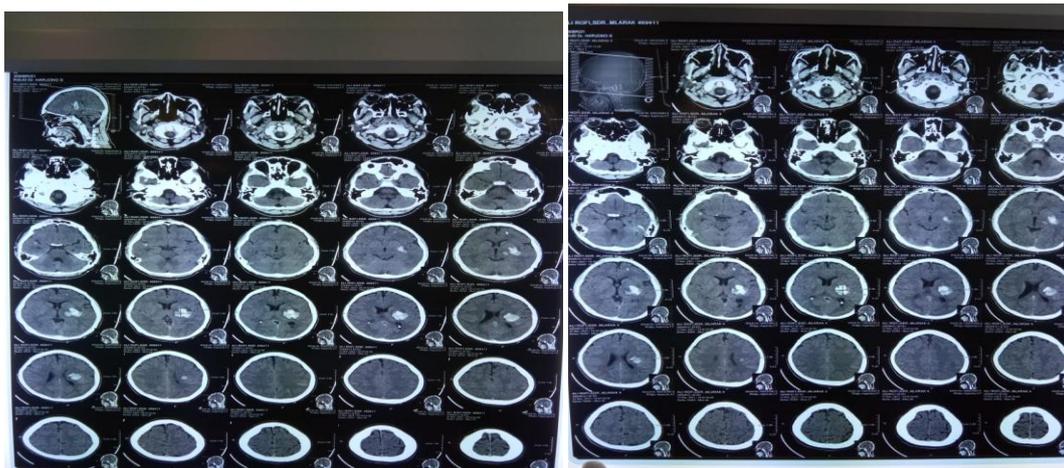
The CT scan of Mr. AR shows that there is bleeding with a size of 3x3,5x4
